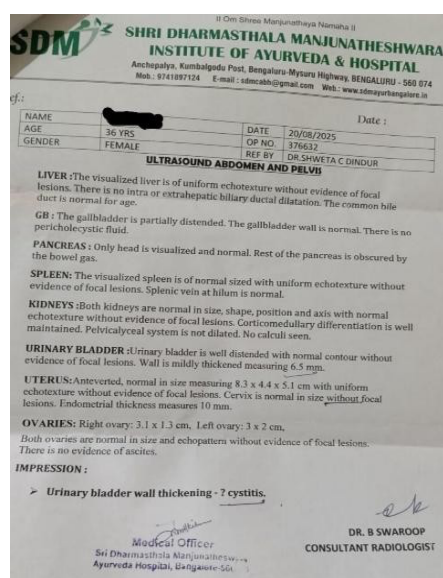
Pre-treatment sonography report (20/08/2025)
